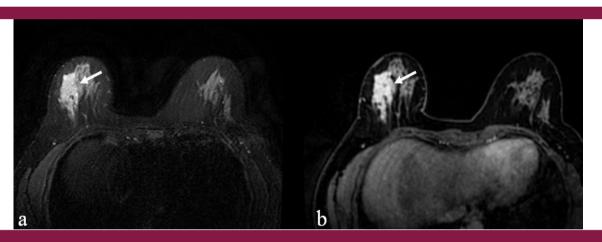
In the DC-MR images of a 40-year-old female patient diagnosed with IGM, a spicular contoured mass (arrow) is observed in the right breast, which is hyperintense in the T2W fat-suppressed series (a) and in postcontrast dynamic displays (b) with intense homogeneous contrast enhancement
